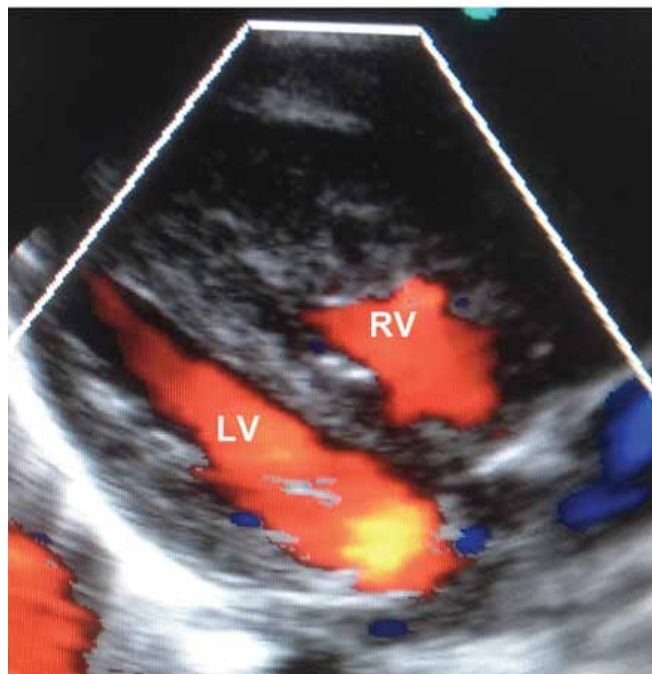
Echocardiogram obtained on the 1<sup>st</sup> day of life; apical four-chamber view showed massive right ventricular hypertrophy with a reduced right ventricular cavity and a normal LV. RV = right ventricle; LV = left ventricle.
